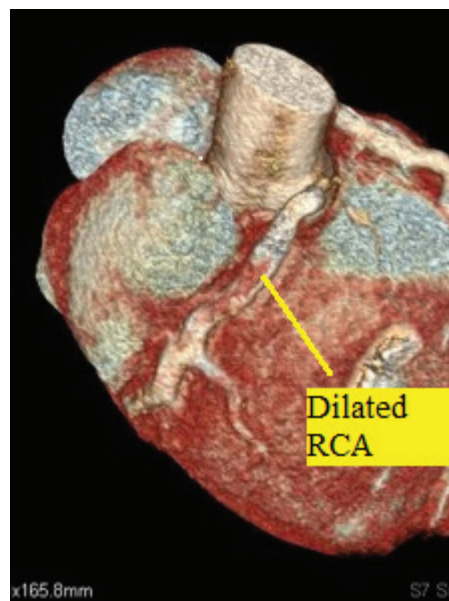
The right coronary artery and circumflex artery of the patient 2 on reconstructed 3D cardiac CT scan
